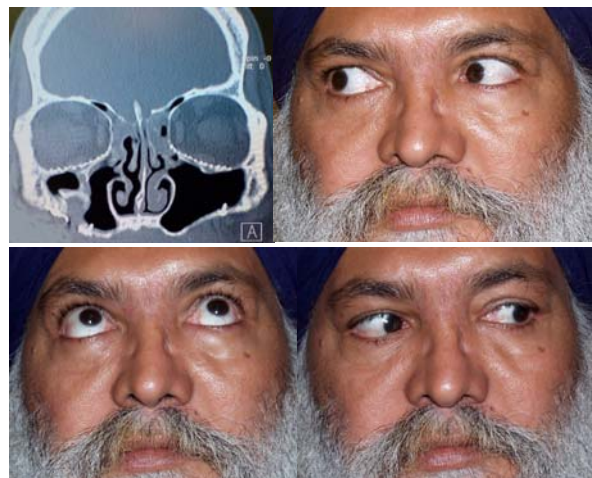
(clockwise from left): CT scan of both orbits with titanium mesh after 1 year, various views of patient moving eyes with no hindrance of movement after titanium reconstruction
